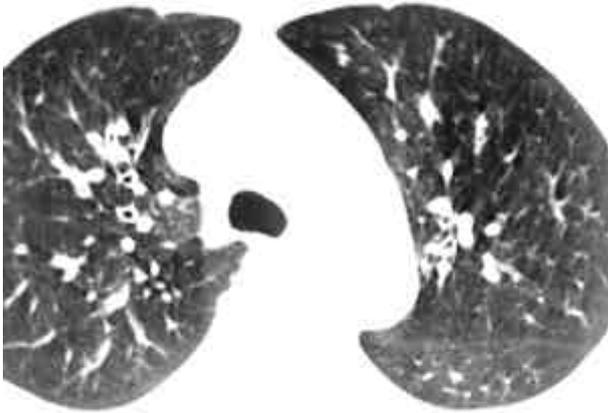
HRCT of case 1 shows bilaterally diffuse bronchial wall thickening and mosaic pattern of heterogeneity of lung densities.
